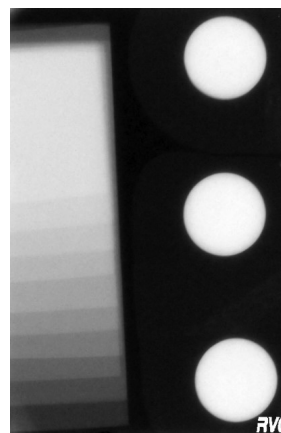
Digital radiograph of Ceraseal sealer and aluminum stepwedge
